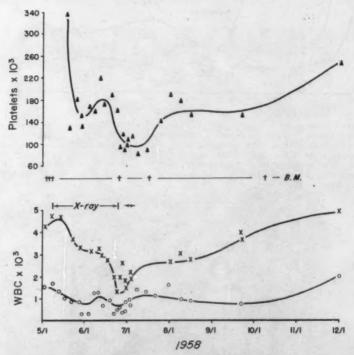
Case 4. Control. May to December, 1958. X-ray factors as for figure 1. Radiotherapy, 5/7/58 to 7/3/58, was to 8 ports, varying from 10 by 10 (supraclavicular) to 20 by 20 (mediastinal) cm., including same ports and rate as figure 1, 2,200 r (tissue) total to the node-bearing regions.
